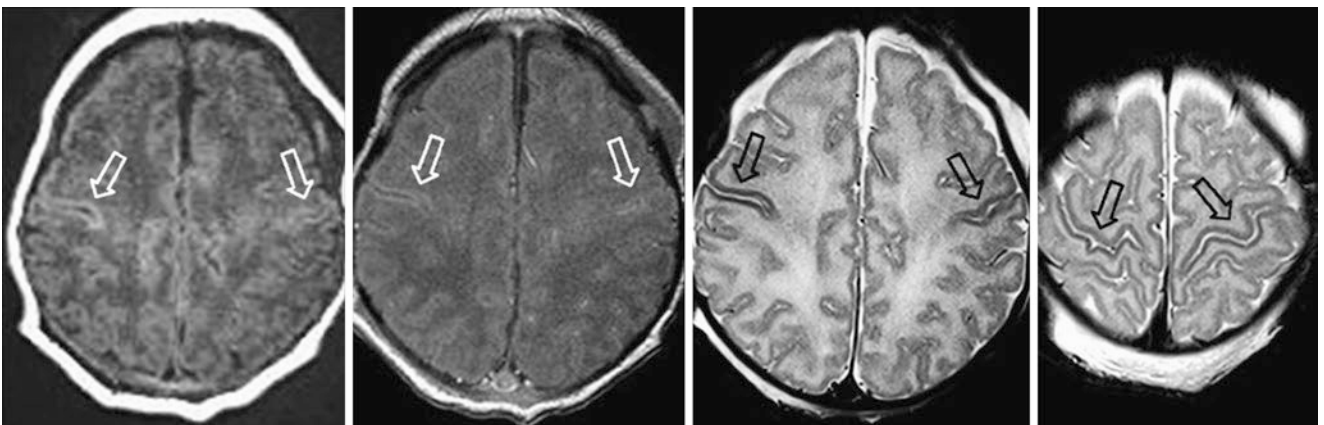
A 4-day-old term neonate had a normal 3T MRI with GE T1WI (*left*), SE T1WI (*left middle*), and SE T2WIs (*right middle* and *right*). The PRC (*open arrows*) is visualized as slightly bright on GE
